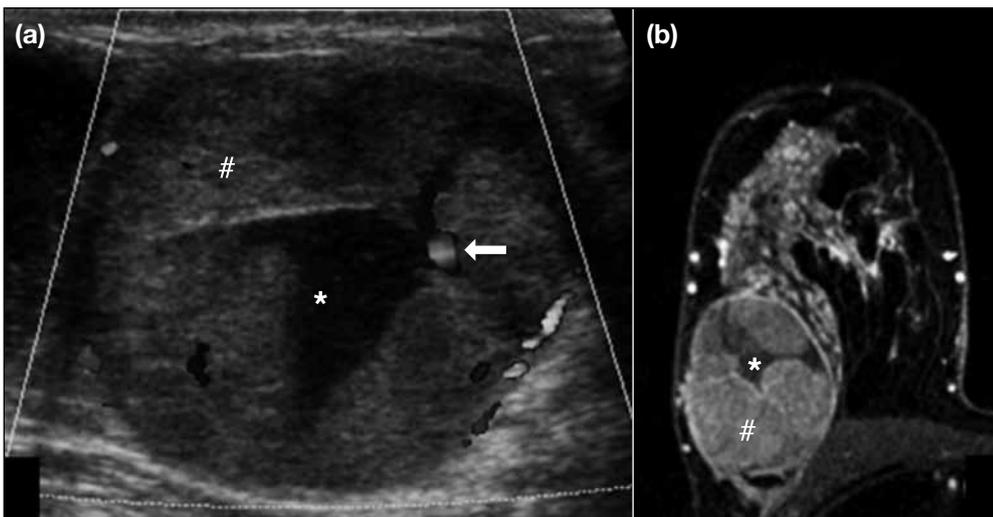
(a) Doppler ultrasound image of a complex solid (#) and cystic (*) mass with oval morphology, circumscribed margins, and intranodular flow (arrow) in the solid component, located in the superolateral quadrant of the right breast in 49-year-old woman. (b) T1-weighted magnetic resonance image after contrast enhancement showing an oval mass with circumscribed margins, complex solid (#) and cystic (*) pattern, and enhancement of its solid portions, located in the superolateral quadrant.
